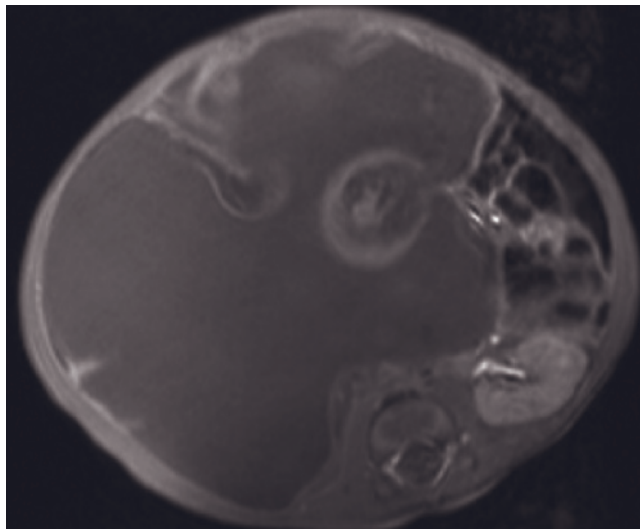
(Continued) T2-weighted fat-suppressed SS-ETSE (f), and transverse interstitial-phase gadolinium-enhanced SGE (g) images in a second patient, who has right testis rhabdomyosarcoma. There is a nodal mass in the aortocaval region that displaces the pancreas anteriorly and the inferior vena cava laterally. Left para-aortic lymph nodes are also identified. Coronal T2-weighted single-shot echo-train spin-echo (b), transverse T1-weighted SGE (i), and transverse T1-weighted postgadolinium interstitial-phase
